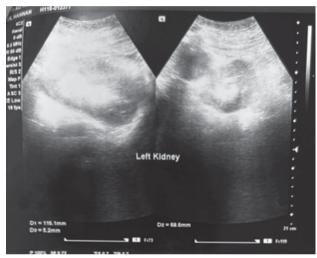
Ultrasound images showing huge ascites with features of AKI
